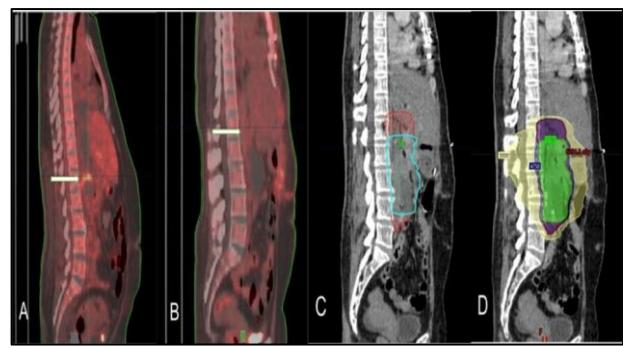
Sagittal views: A) pre-operative PET CT scan (white arrow showing FDG uptake), B) post-operative PET CT scan (absence of FDG uptake), C) treatment volume, D) dose distribution (yellow: 50% isodose of total dose, 3000cGy; blue: 95% isodose of total dose, 5700 cGy; green: 95% isodose of phase I, 4750cGy).
